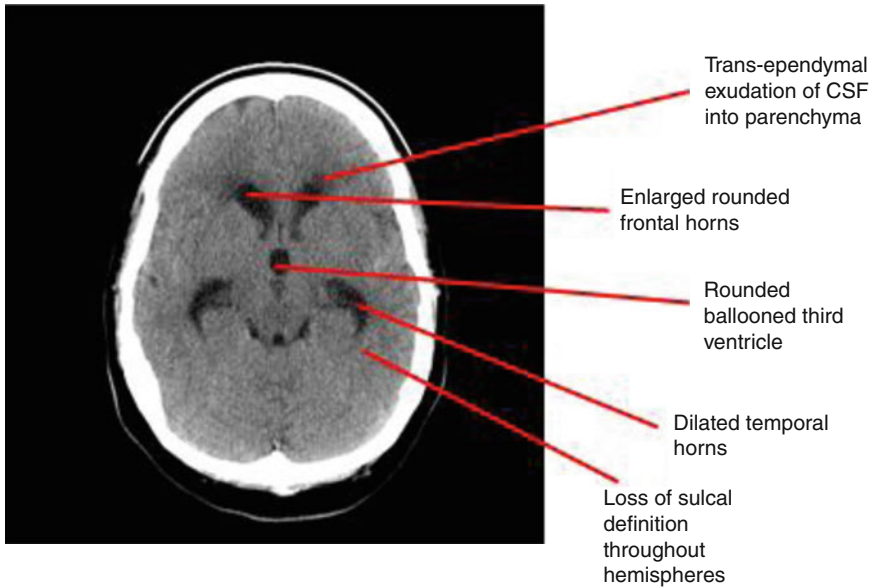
Axial CT showing acute hydrocephalus
